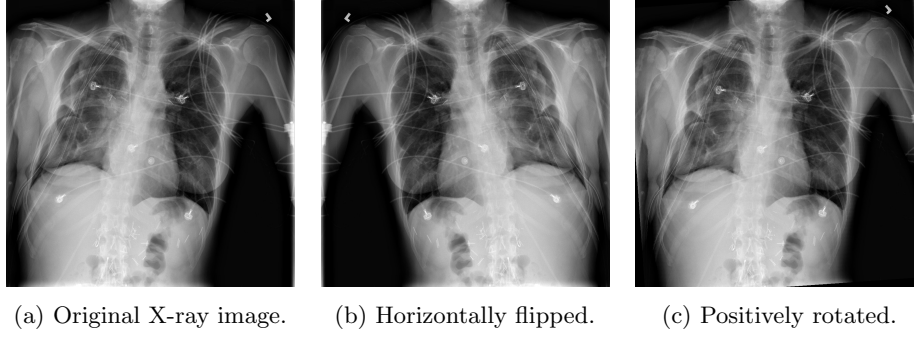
Sample chest X-ray image along with the applied augmentation.
